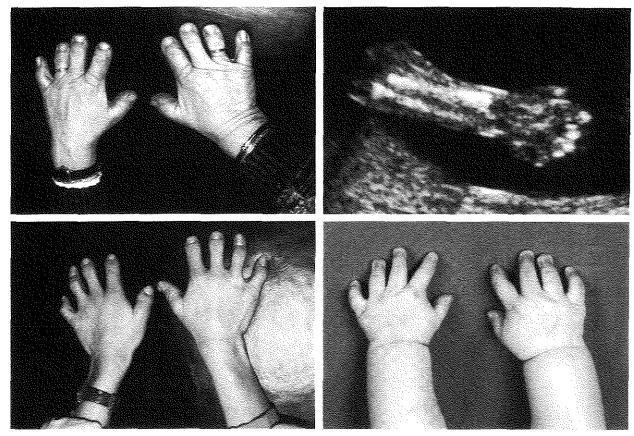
Photographs of the hands of the mother and grandmother of the fetus and an ultrasound picture of the fetal hand (the thumb and index finger are extended; the other fingers are somewhat bent), showing type A1 brachydactyly.
